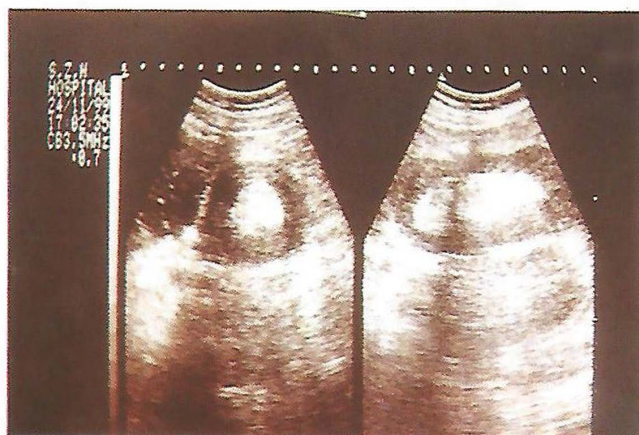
Transverse and longitudinal sonographic examination demonstrating the donut and pseudo-kidney sign of intussusception.
